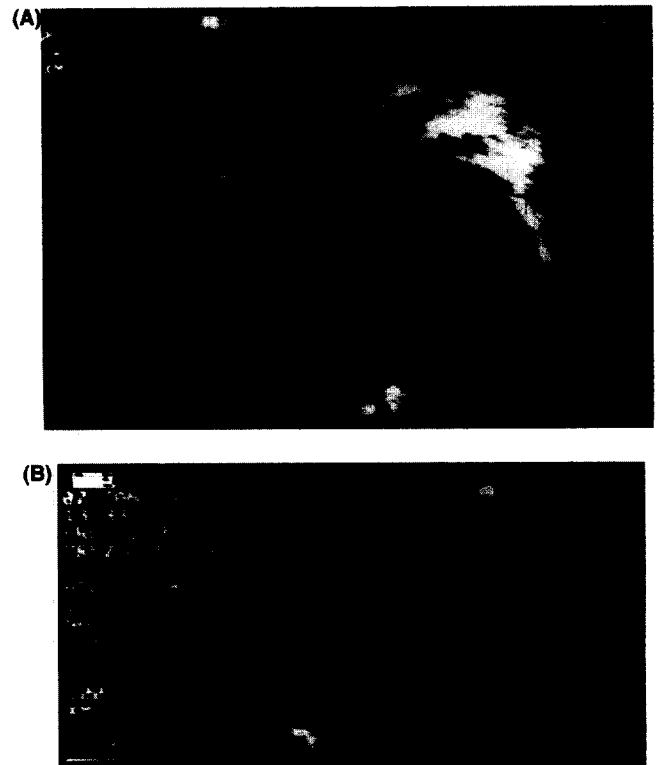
(A) Preoperative echocardiographic examination: left ventricular long axis view. The arrow indicates the accessory mitral valve tissue in the subaortic area. A large membranous ventricular septal defect with muscular extension can also be seen. (B) Intraoperative epicardial echocardiography using a 7.5-Mhz transducer: an echodense patch closing the VSD can be seen. No abnormal tissue in the subaortic region was observed. Ao, Aorta; LV, left ventricle.
